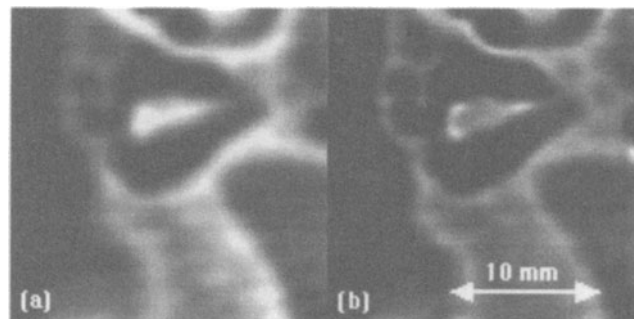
Digital deblurring of a spiral CT image. (a) A spiral CT image through the incus scanned using a cochlear implantation protocol, (b) post-processed using the EM-like iterative deblurring algorithm.
